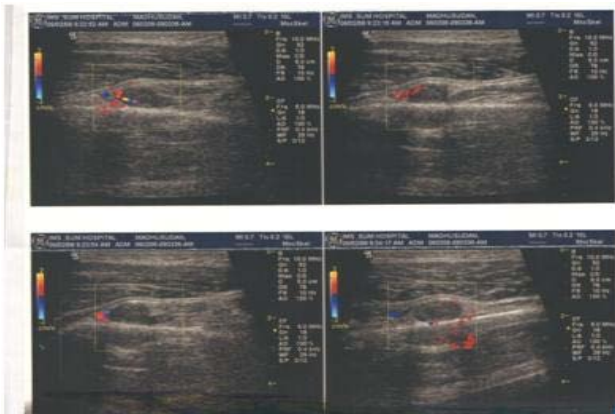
Ultrasonography of thigh (neurilemoma as hypoechoic lesion under periosteum)
